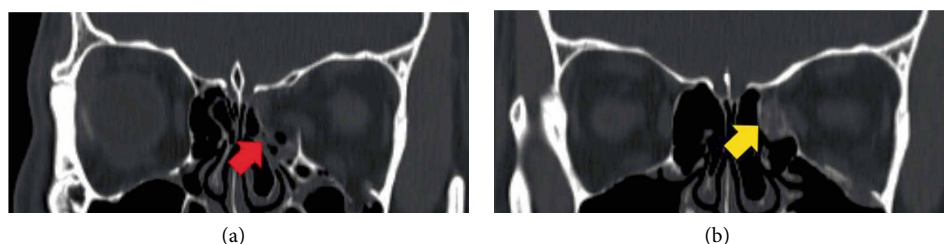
CT images of the case 1 patient. Preoperative CT scan shows fracture and bone defect in the medial wall of the left orbit (a, red arrow). The orbital contents are well maintained inside the orbit by combination plate. Note the weak signal intensity of bone formation in the postoperative CT scan obtained at 12 months after operation (b, yellow arrow).
